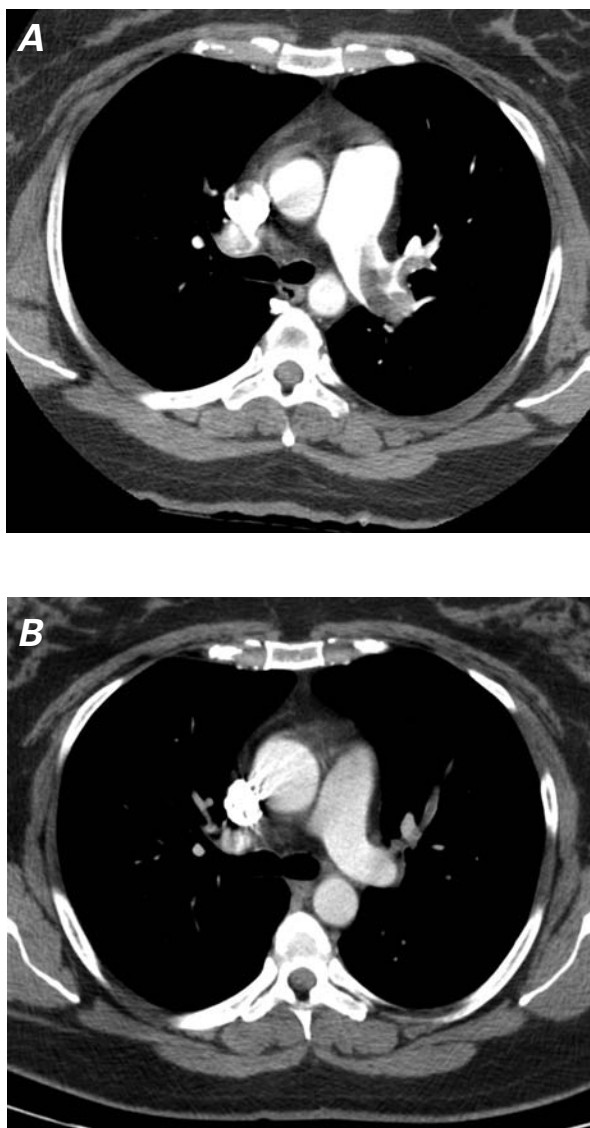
Patient 8. Computed tomographic scans of the chest show a massive pulmonary embolus A) before thrombolysis and B) after the resolution of the thrombus.
